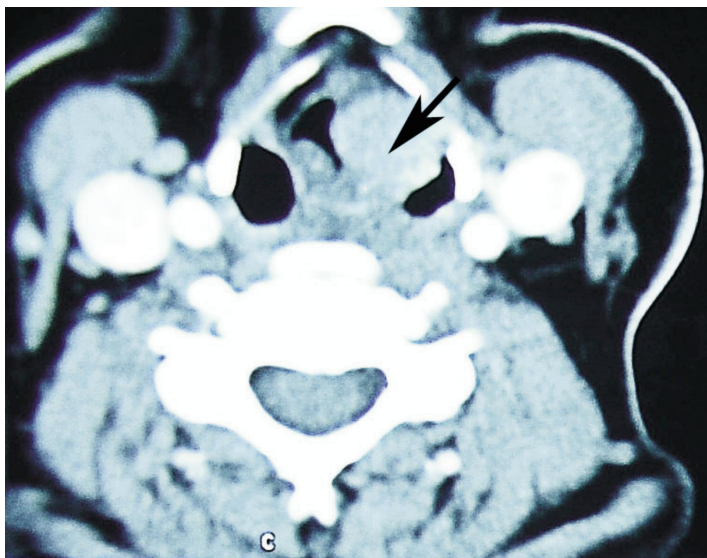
Axial contrast-enhanced CT scan of the larynx of a 56-year-old woman with hoarseness for 6 months and dysphonia for 1 week
